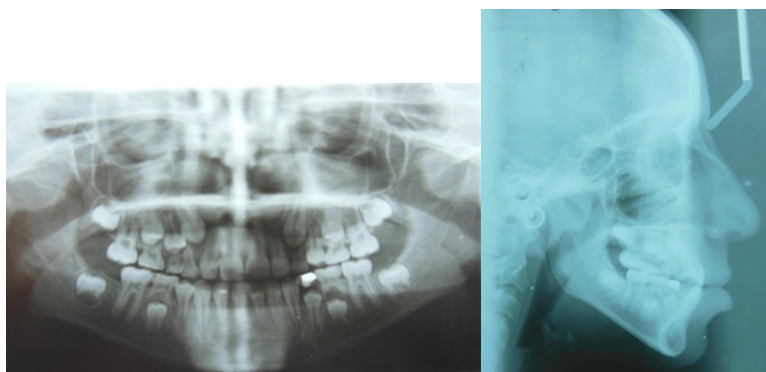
Radiographic Examination.
